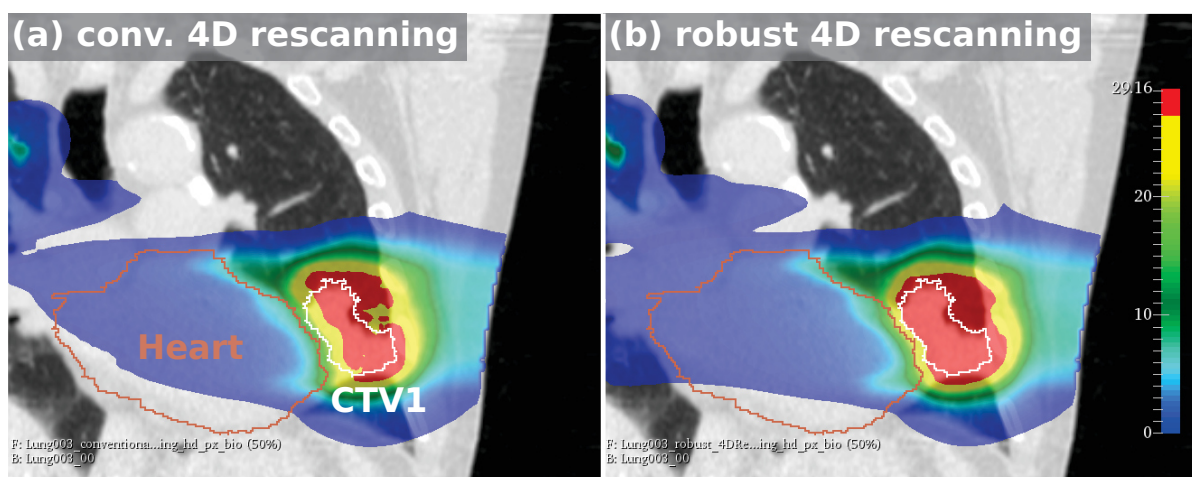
Coronal dose distribution of patient 3, exemplarily showing the deteriorated dose distribution of the conventional 4D rescanning plan (a), compared to the robust 4D rescanning plan (b), in the presence of range undershoot (increased CT density) and a horizontal setup shift in direction of the heart. The conventional 4D rescanning plan produces cold spots and fails to cover the complete target with dose.
